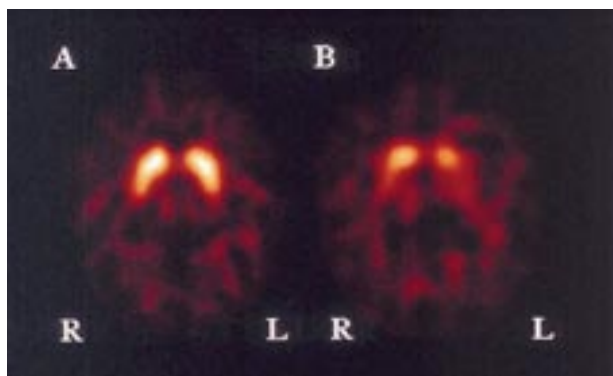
[ $^{123}\text{I}$ ]FP-CIT SPECT images obtained 3 h after injection of the radiotracer of (A) 65-year old healthy woman and (B) 59-year old female patient with hemi-Parkinson's disease (Hoehn and Yahr stage I). Transversal slices from brain at the level of the striatum (approximately 3 cm above orbitomeatal line) (L = left side; R = right side). In both images, level of activity is color coded from low (black) to high (white) and scaled to maximum in the slice of the healthy woman. Note the lower striatal (especially in the putamen) and asymmetrical activity in the patient compared to the healthy volunteer.
